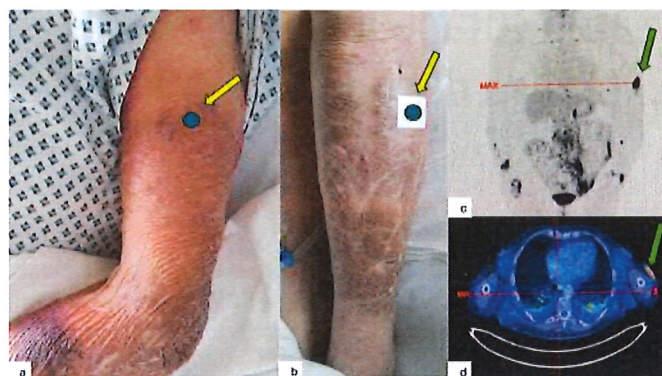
(a) Diffuse erythematous infiltrations of the upper arm (Yellow arrow: biopsy site), (b) Diffuse erythematous infiltrations of the leg, carton-like skin and scarring (Yellow arrow: biopsy site) and (c, d) PET/CT revealing hypermetabolic cutaneous and subcutaneous infiltrations (Green arrow: biopsy sites).
